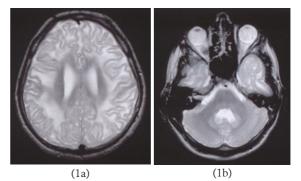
T-2 weighted MRI images showing subcortical and periventricular white matter involvement with bilateral symmetric dentate nuclei lesions.
